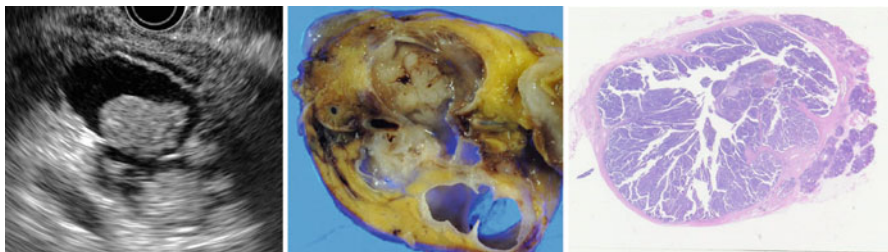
MNs in the dilated branch (mixed-type IPMN). EUS detects the MNs as hyperechoic masses because of ultrasonic scattering by the papillary structures
